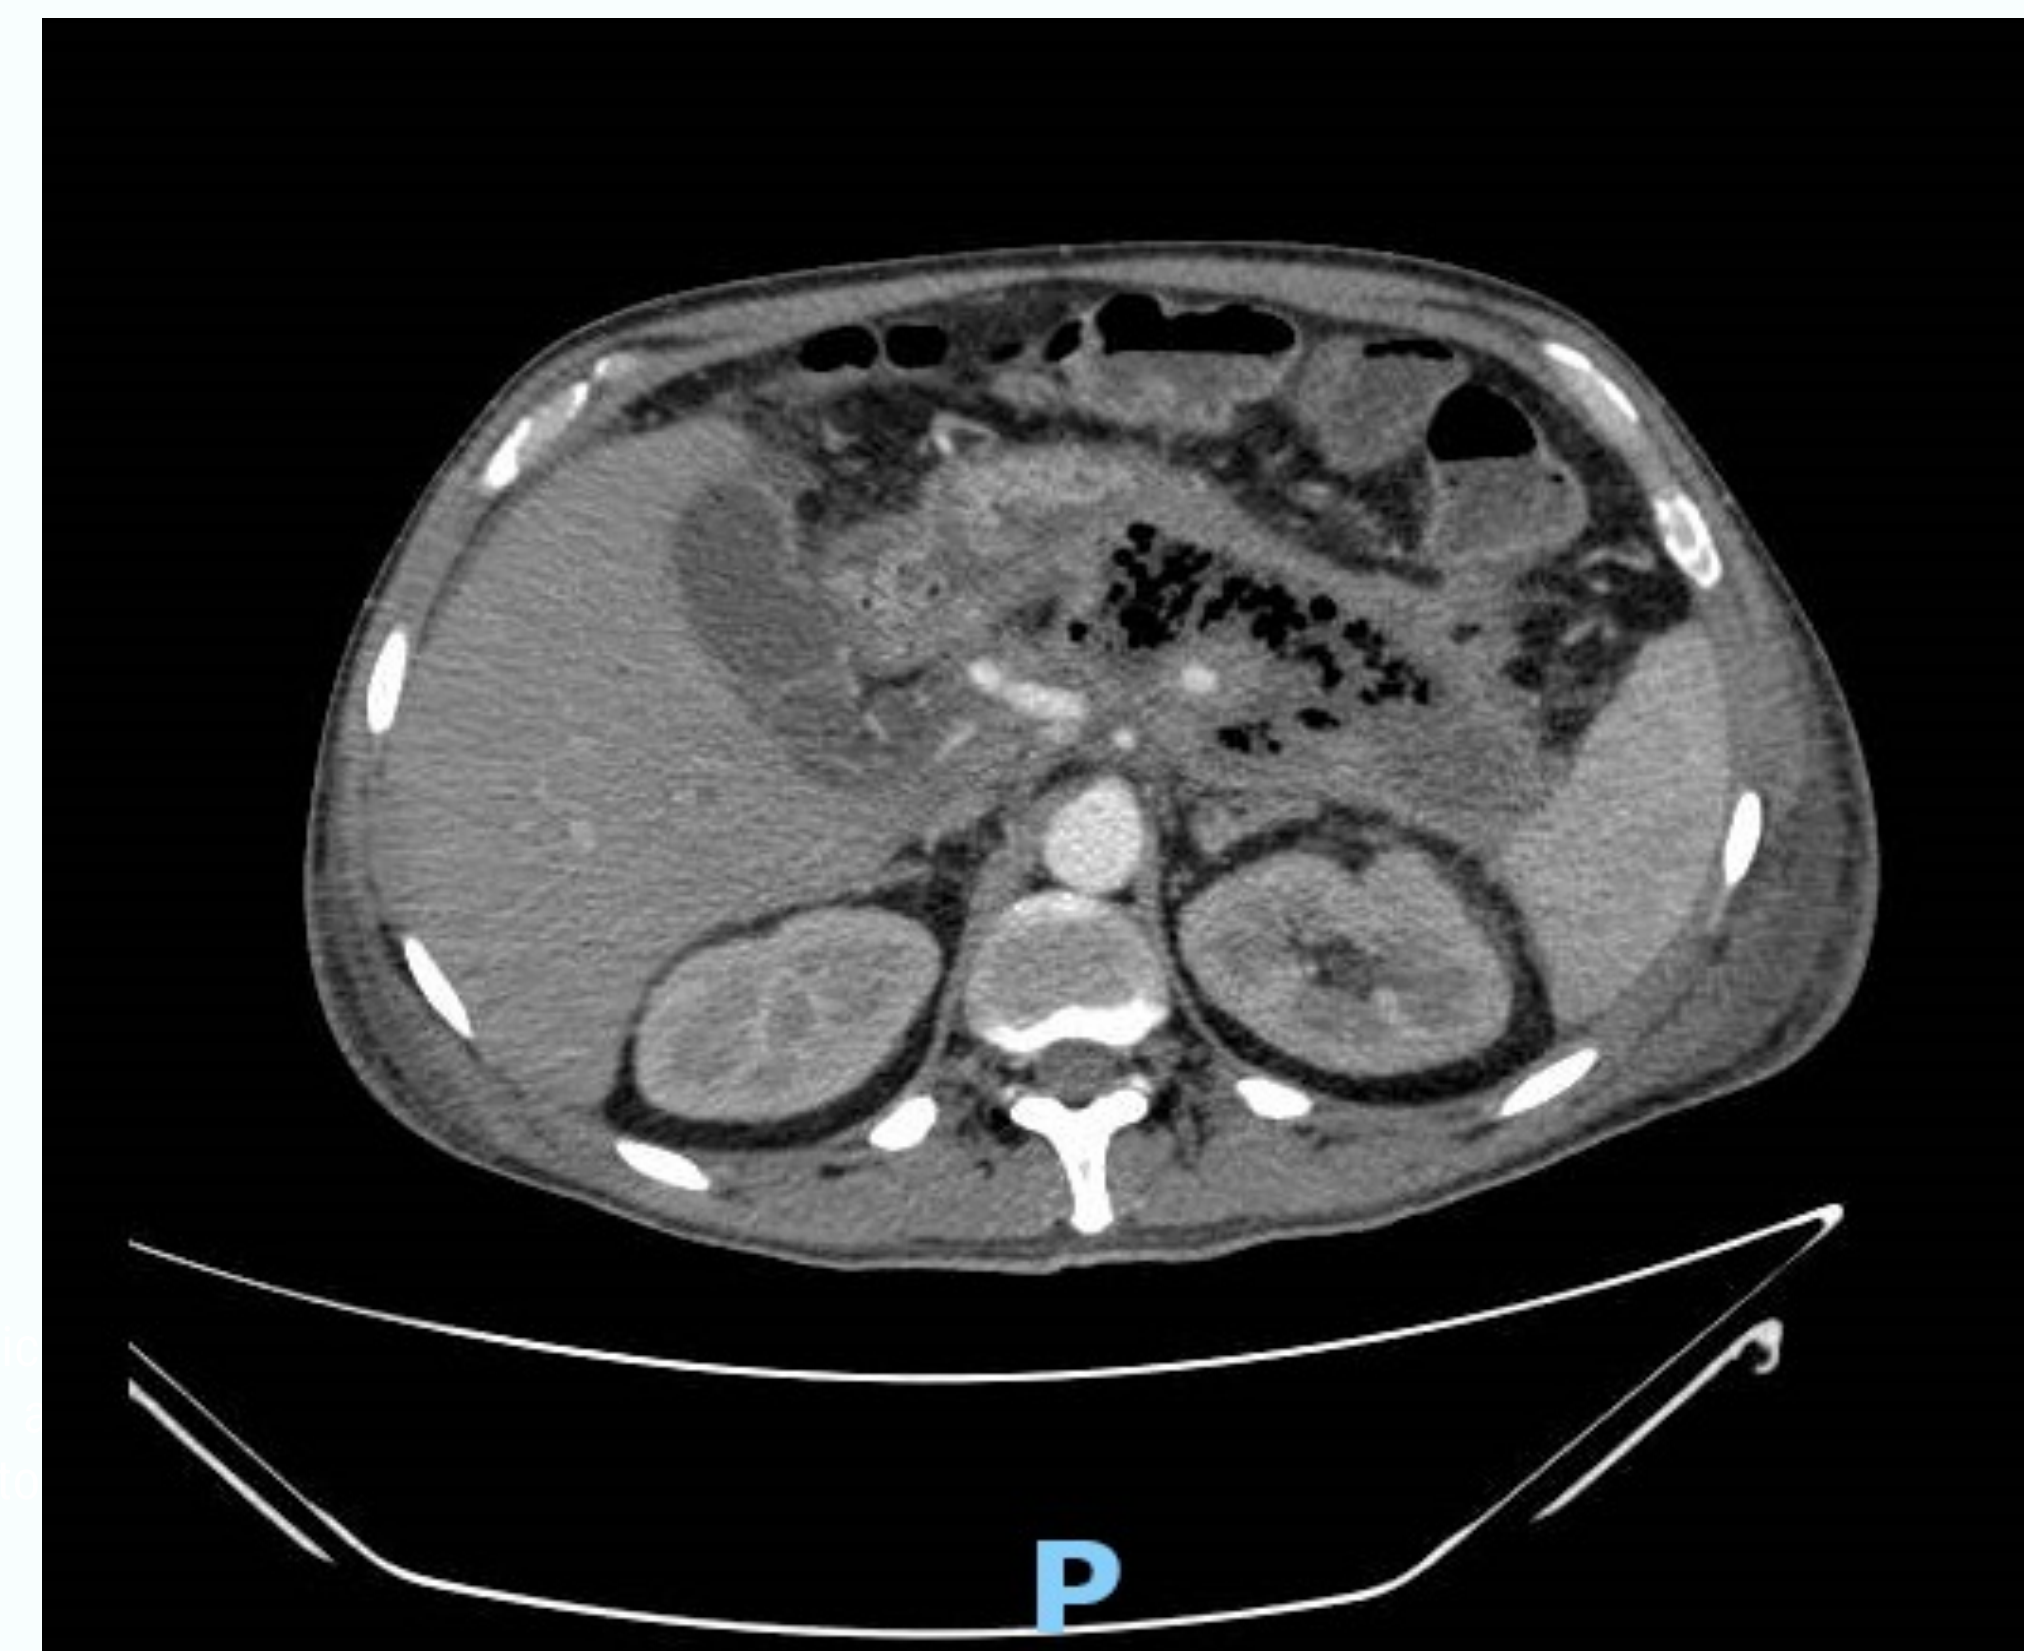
Abdominopelvic CT with IV contrast now with interval gas development within the multiloculated fluid collections, strongly suggestive of partial drainage versus infection with a gas-forming bacteria.
